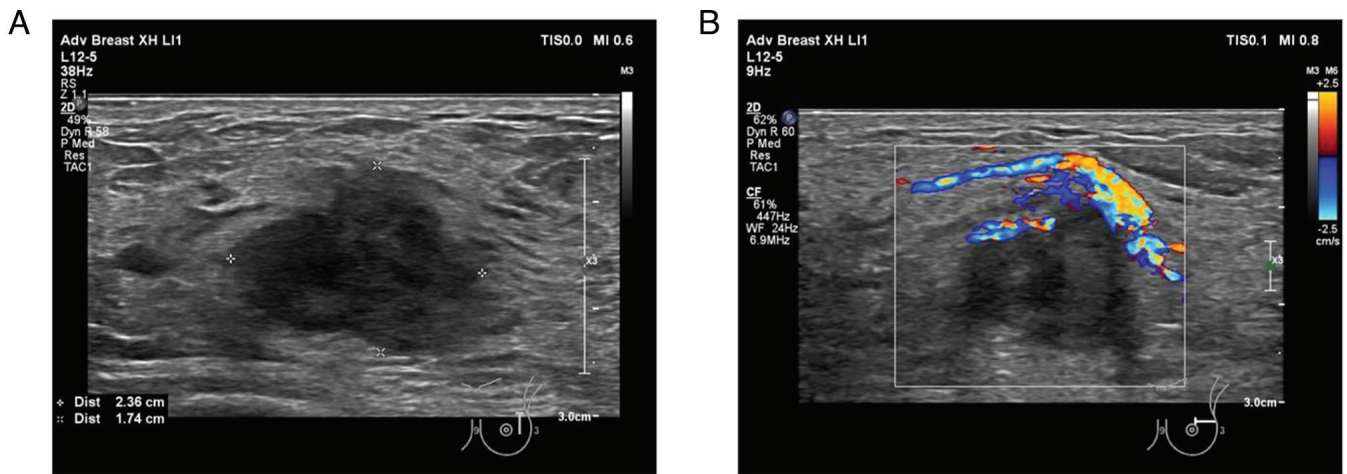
Ultrasound images. (A) A hypo-echoic lesion with an irregular shape and small lobulated visible, and with (B) rich and large blood flow signals around the periphery.
